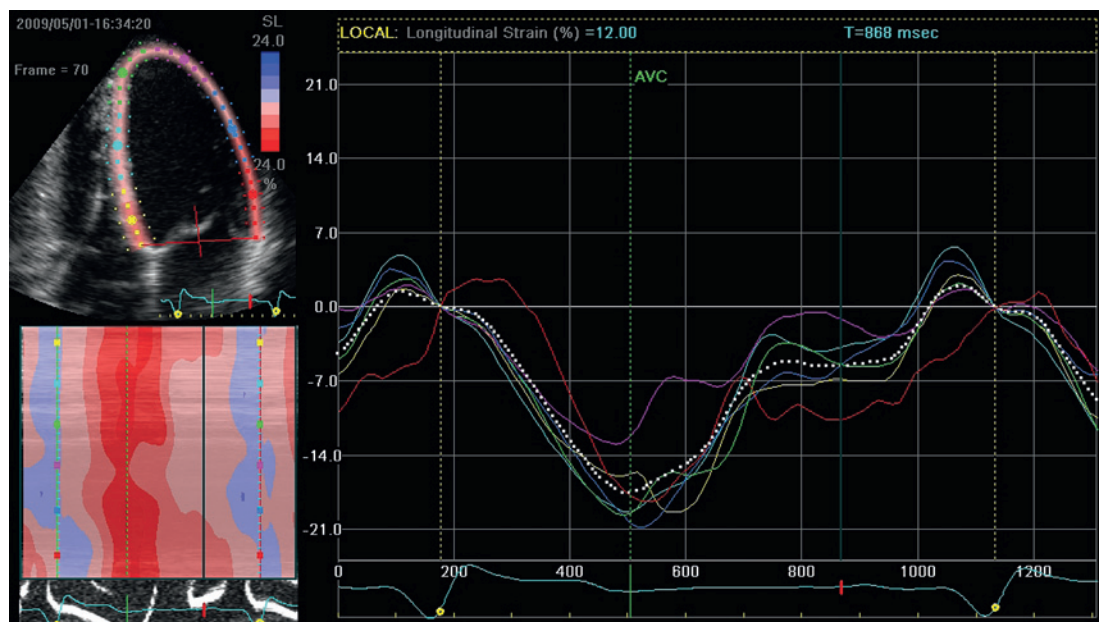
Segmental curves representing regional longitudinal left ventricular strain in the apical four chamber view as determined by speckle tracking echocardiography.
